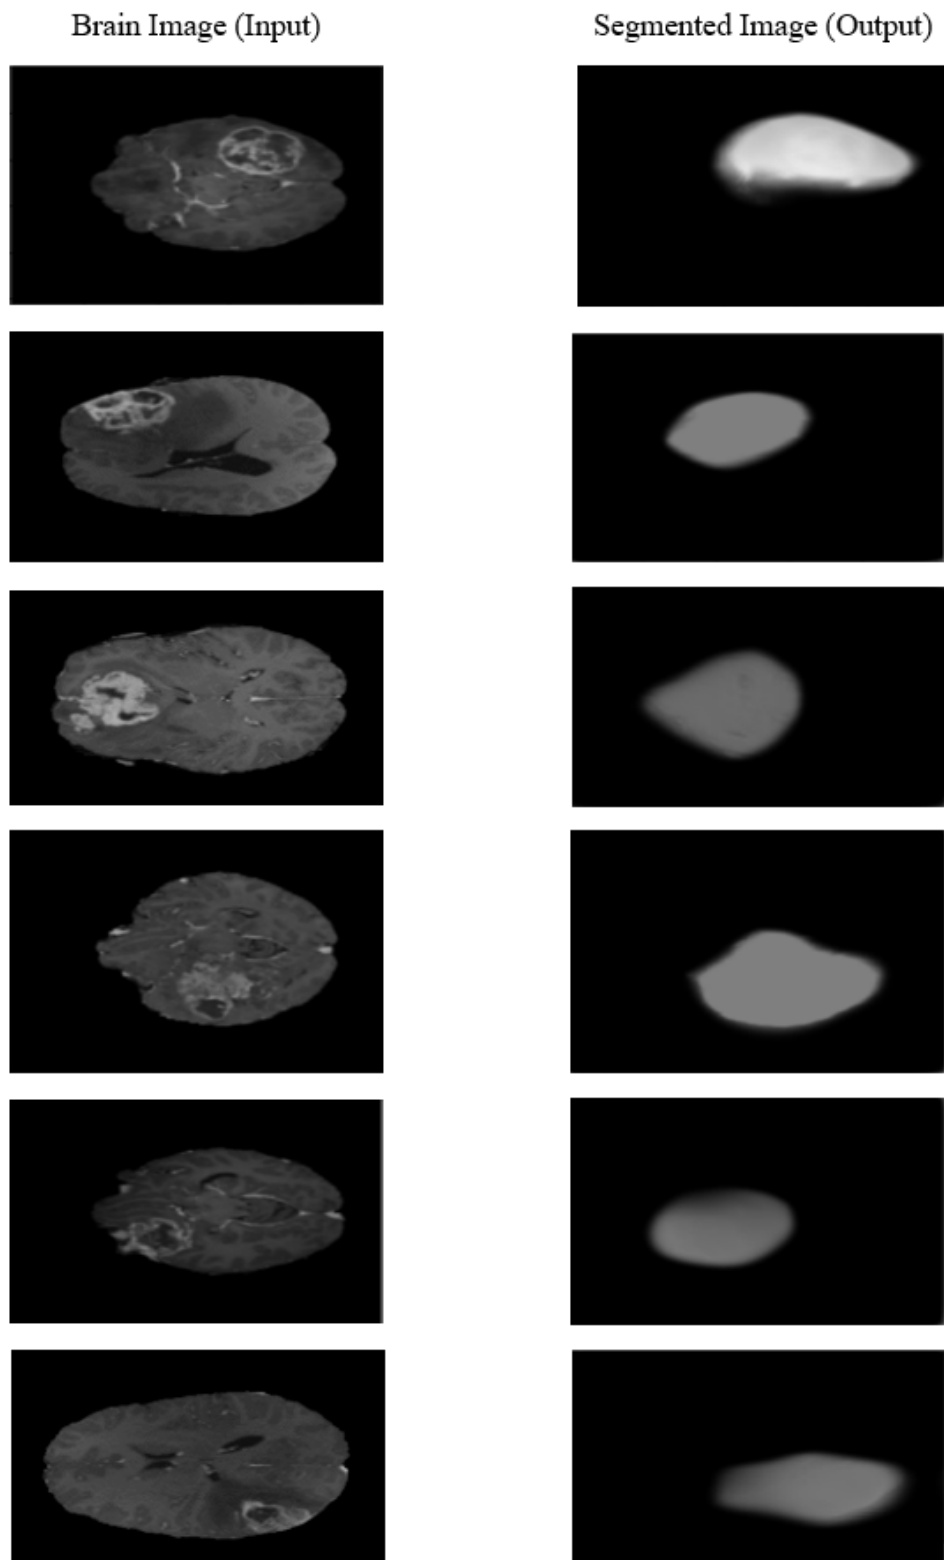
Semantic Segmentation of tumor region from 3D MRI (T1ce) input brain images.
